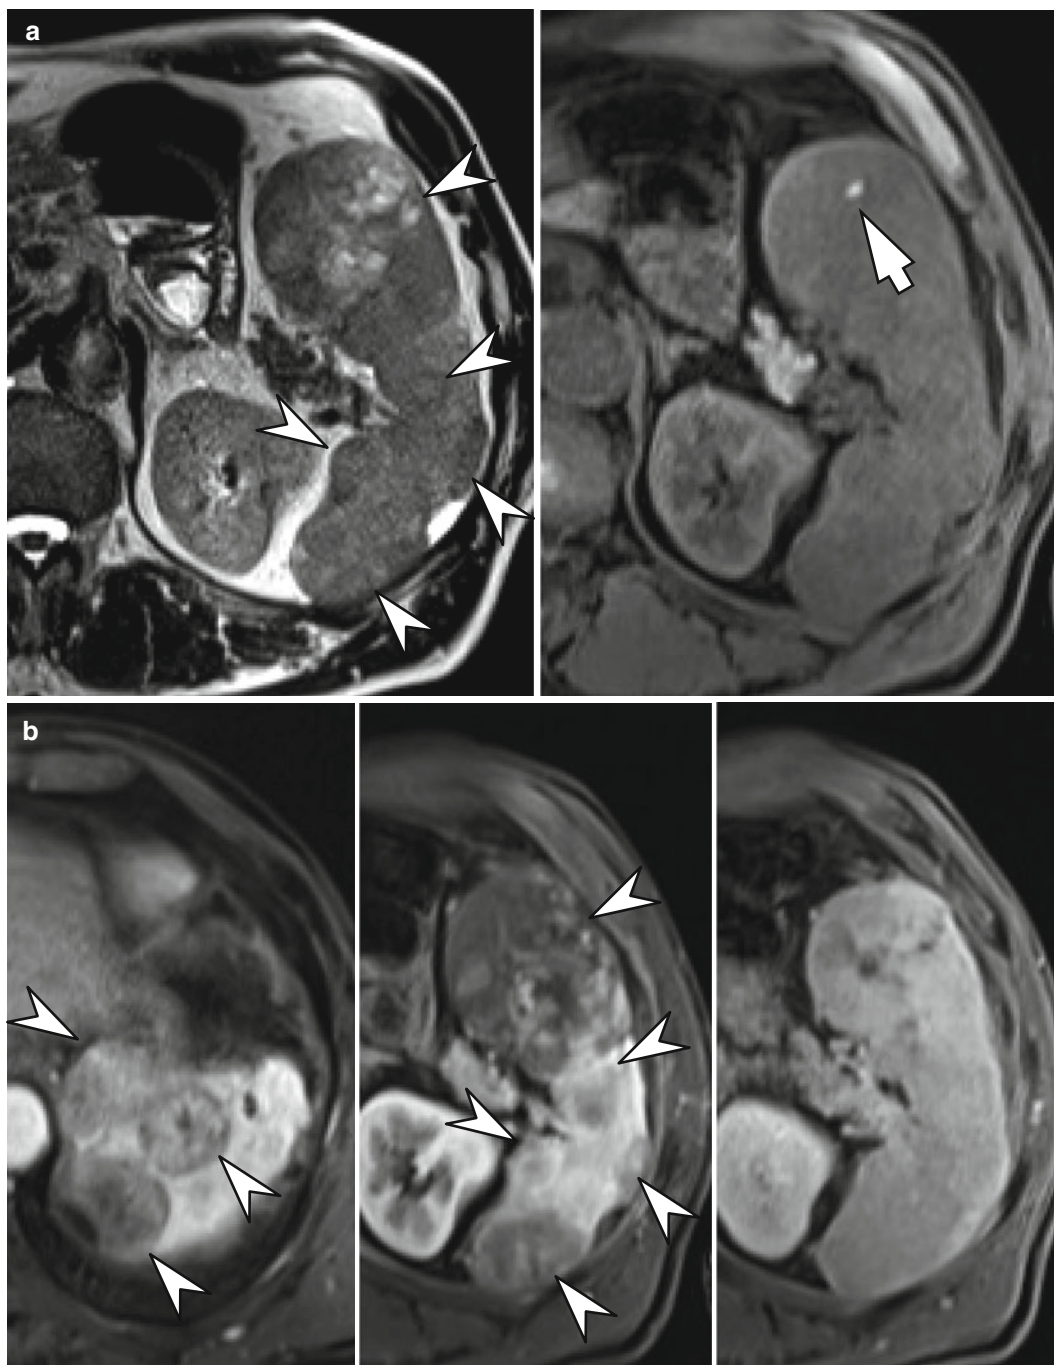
Splenic angiosarcoma in a 63-year-old male. (a) T2-weighted transverse MRI (left) shows multiple masses (arrowheads) of variable signal intensities in the spleen. A bright dot (arrow) on fat-saturated T1-weighted transverse MRI (right) suggests intratumoral hemorrhage. (b) Contrast-enhanced portal phase T1-weighted transverse MRI
